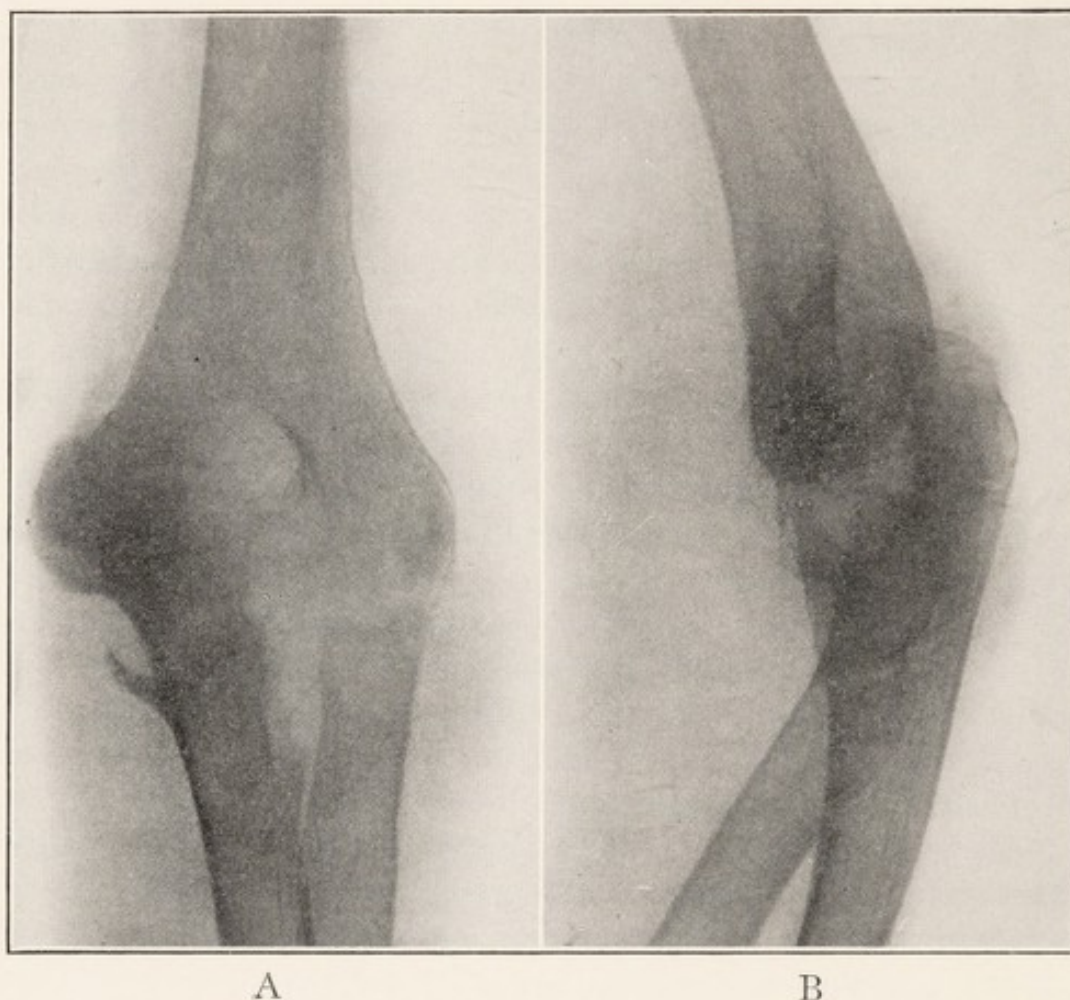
X-RAY SHOWING TUBERCULOSIS OF ELBOW JOINT WITH EXTENSIVE DESTRUCTIVE CHANGES, ANTEROPOSTERIOR VIEW.
